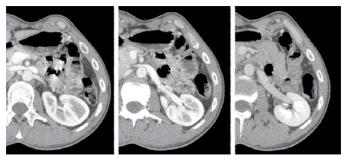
Computed tomography angiography showing Left renal vein compression between the aorta and the superior mesenteric artery with distended hilar portion of the left renal vein.
